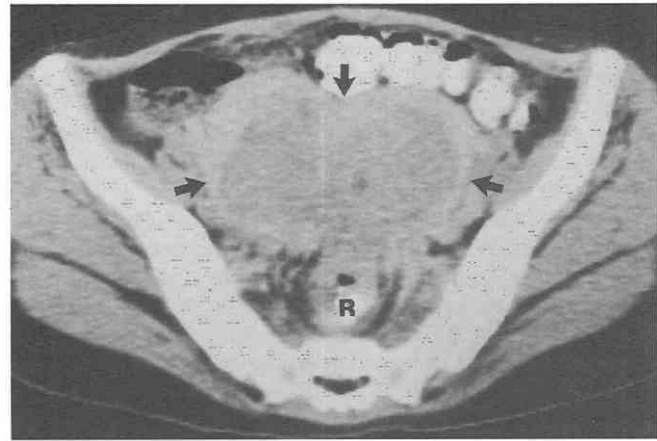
Actinomycosis. A large, bilobed, heterogeneous mass (arrows) in the ovary and bowel wall thickening of the rectum (R) are seen. (From Ha HK, Lee HJ, Kim H, et al: Abdominal actinomycosis: CT findings in 10 patients. *AJR Am J Roentgenol* 161:791-794, 1993.)
